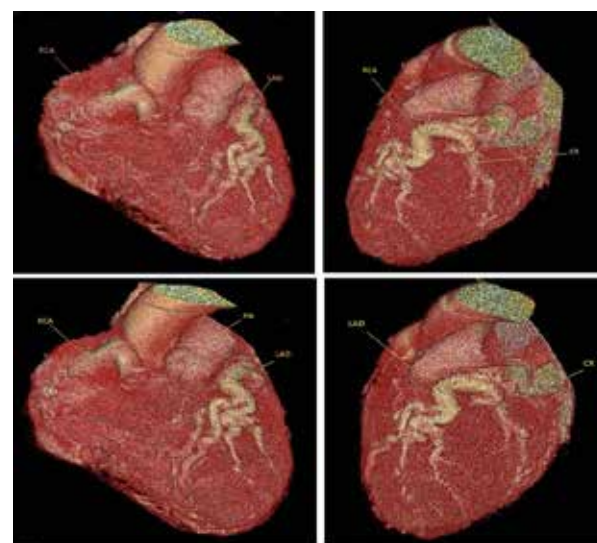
Pre-operative computed tomography imaging.
